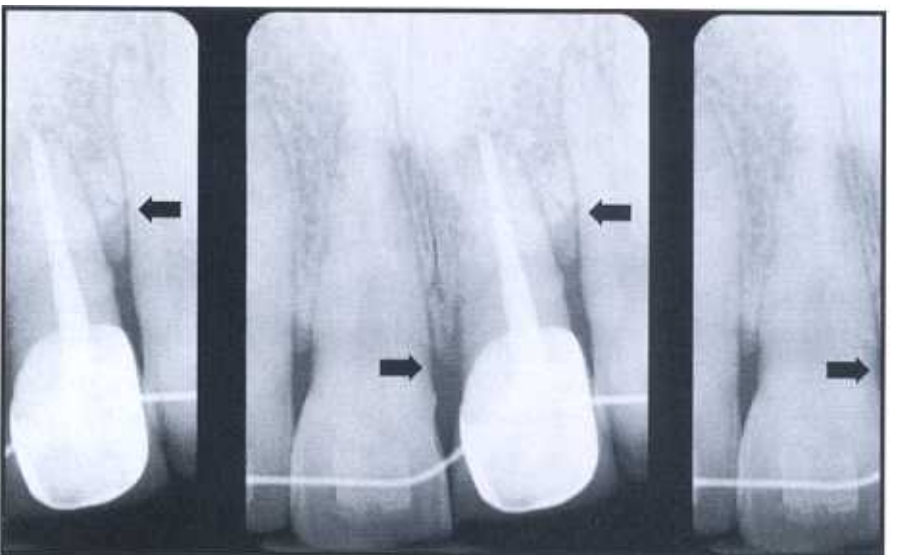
X-ray is taken at initiation of orthodontic eruption to vertically augment labial crest by relocating it coronally.
